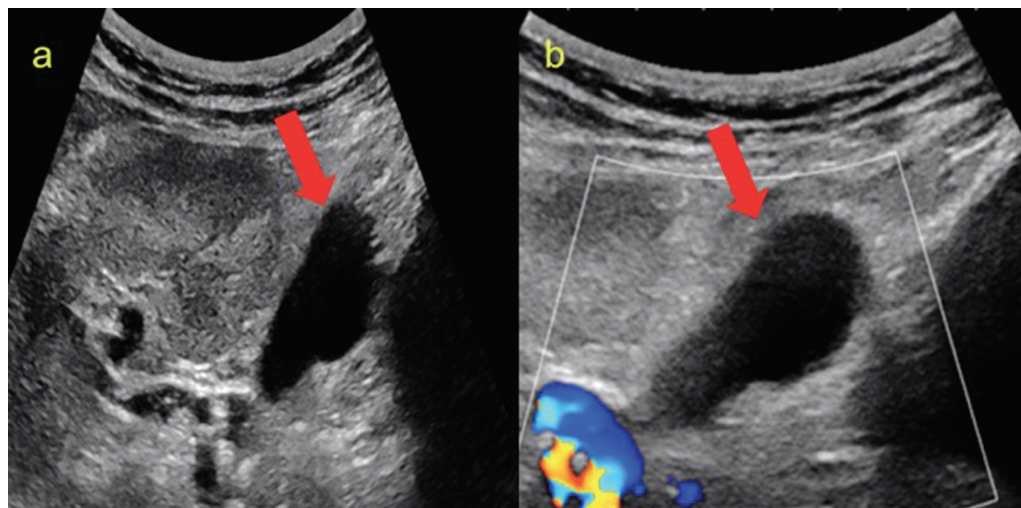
USG of the transplanted kidney (a) and (b) in a 33-year-old male patient (renal transplantation—1 week ago) shows well-defined anechoic collection on B scan with no vascularity on the doppler scan adjacent to the lower pole of the kidney (red arrows), suggestive of urinoma. Aspiration from the collection shows elevated creatinine compared to serum creatinine, confirming the diagnosis. USG, ultrasonography.
